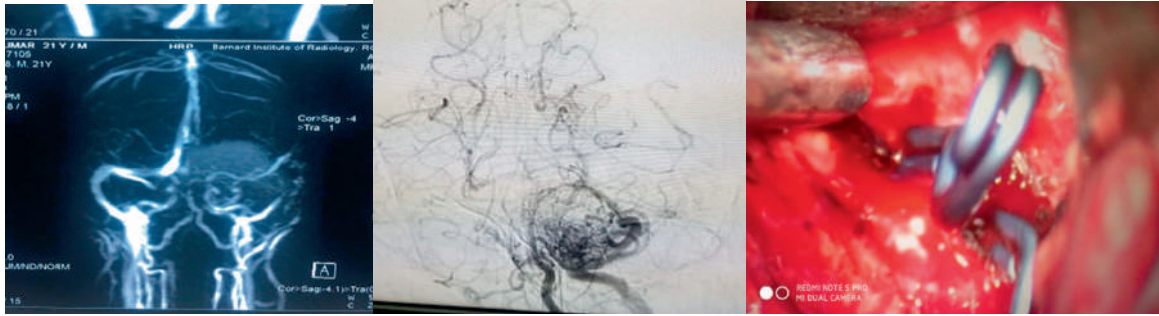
& 5C: MRI Angiogram showing left cerebellar AVM & DSA showing left cerebellar AVM
